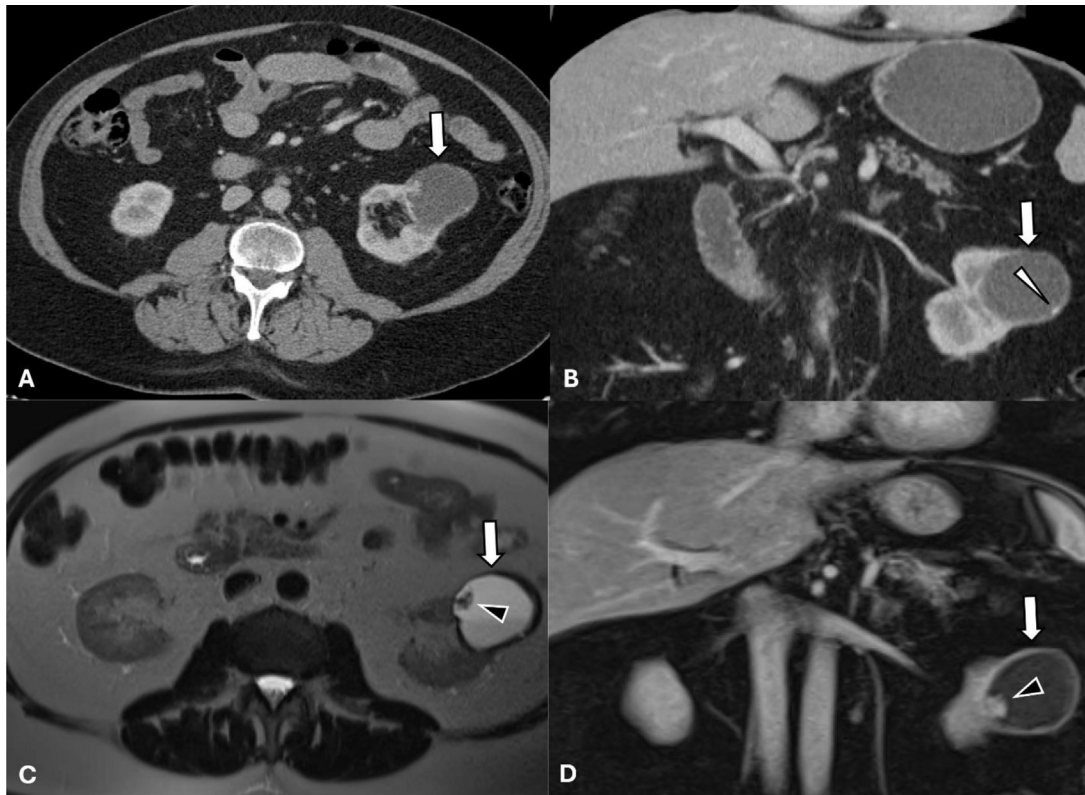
75-year-old found to have a complex left renal mass incidentally. Axial (A) and coronal (B) portal venous phase contrast-enhanced CT demonstrated a left cystic structure with an enhancing mural nodule (arrows) and tiny peripheral calcification (white arrowhead). Axial T2 (C) and coronal T1 postcontrast (D) demonstrate a well-circumscribed, complex exophytic cyst that arises from the lateral interpolar cortex with thick enhancing walls. A 1.3 cm mural nodule (black arrowheads) along the anteromedial wall of the cyst is T2 hypointense and enhancing.
